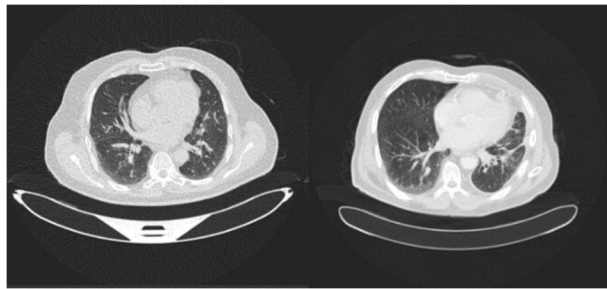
Figure (a) Benign CT Scan Image (b) Malignant CT Scan Image
